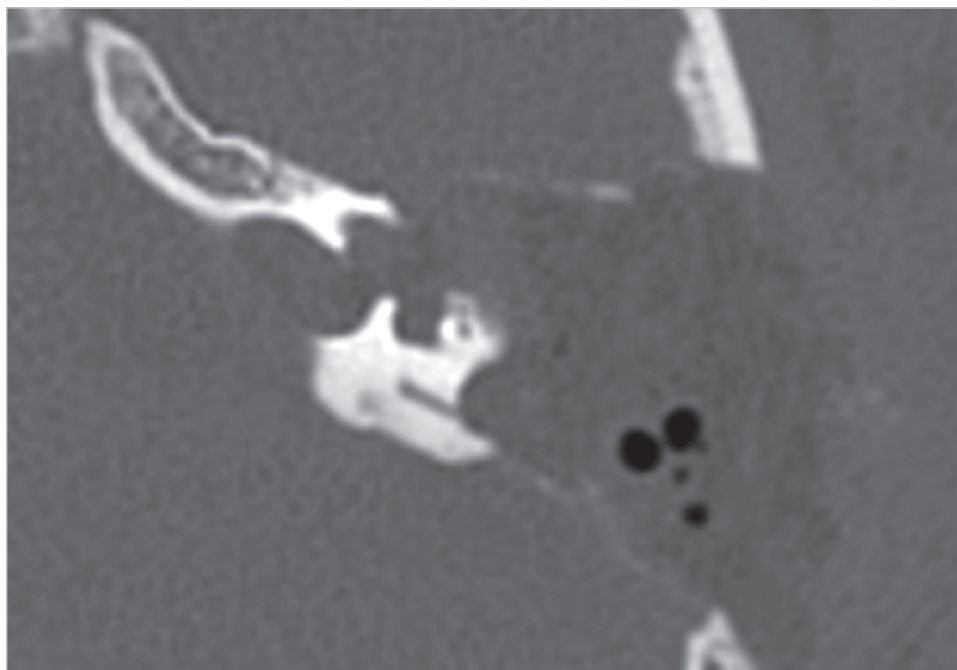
The postoperative CT demonstrates removal of lateral part of the labyrinth cochlea.
